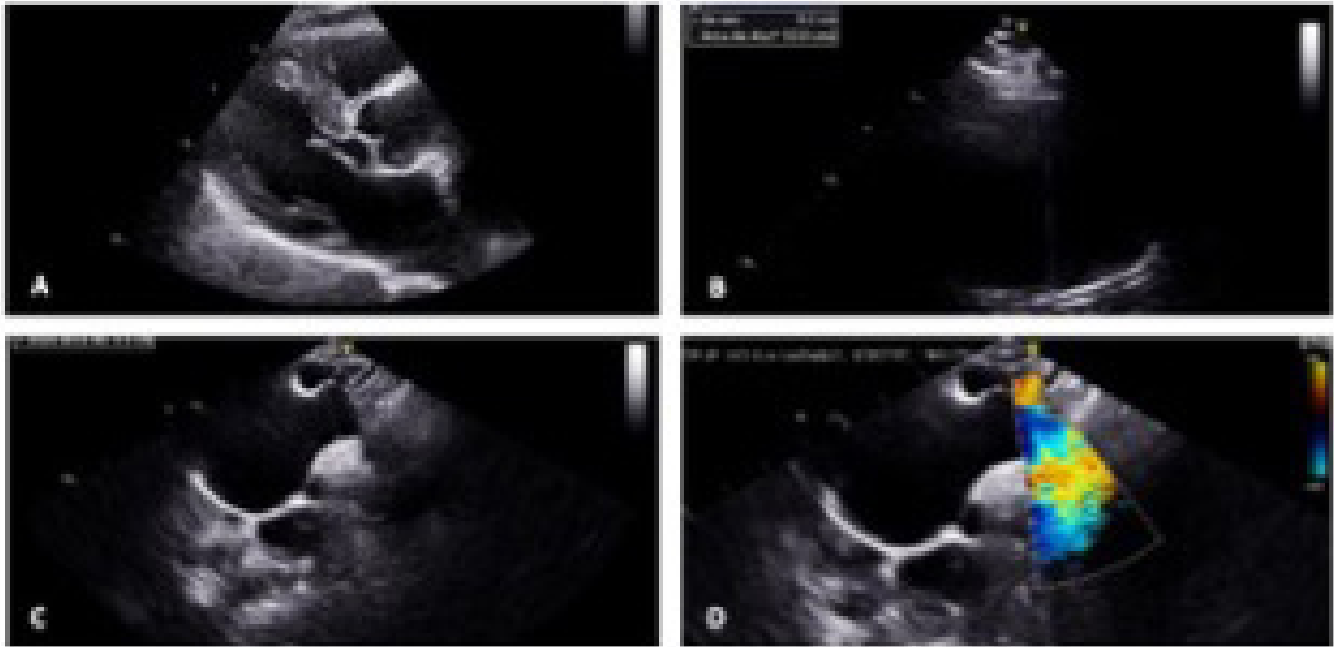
Transthoracic echocardiogram performed before surgery. A) Aortic valve and sinotubular junction. B) Ascending aorta aneurysm. C) and D) Distal portion of ascending aorta and Doppler color suggesting dissection.
